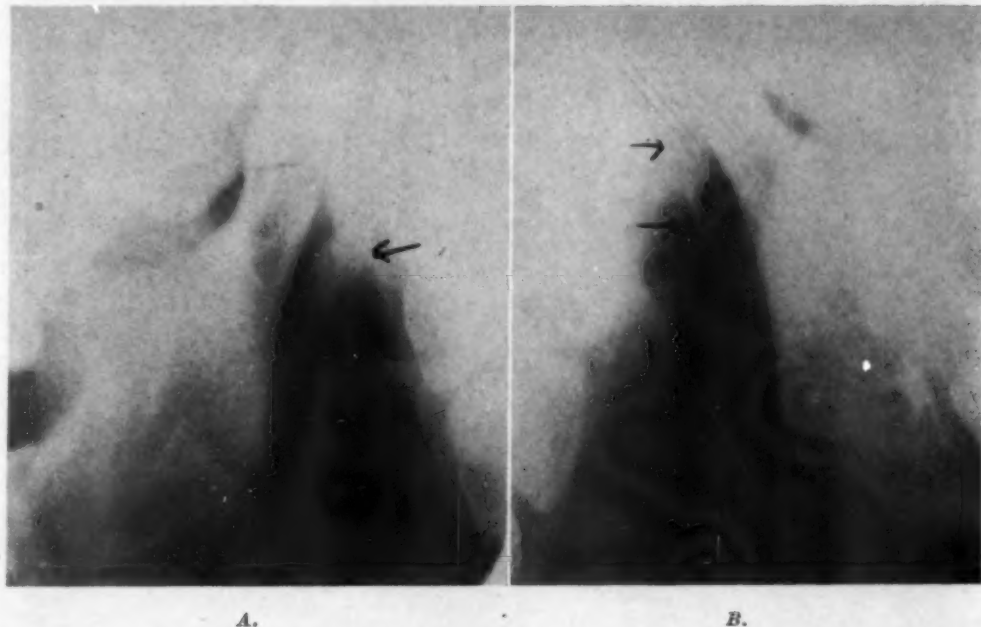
A* and *B*, Showing the dissimilarity in size and form of the styloid process of the right and left side of the same individual. *A*, The right side caused a small swelling to appear on the external surface of the neck posterior to the ascending ramus, which was being treated with x-ray therapy.
